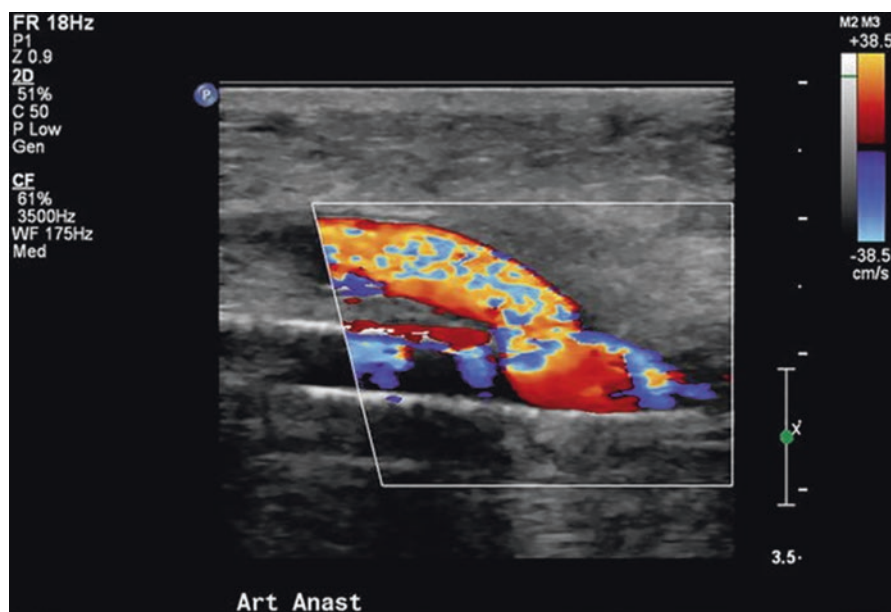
Color Doppler image of the same arterial anastomosis as in Fig. 10.1 demonstrating turbulent flow within the arterial limb of the graft. Note that there are areas of both blue and red, indicating turbulence. This is a normal finding at a dialysis access arterial anastomosis but would be considered abnormal in a native artery
